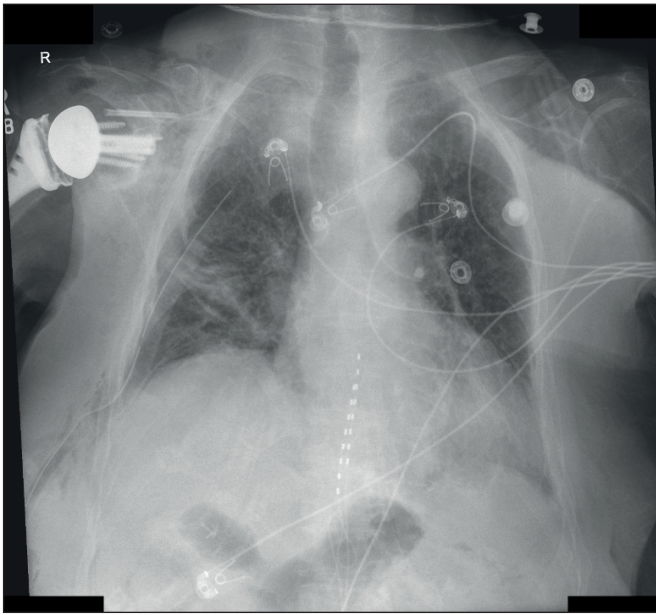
Chest X-ray after right chest tube placement with improvement of the right pneumothorax.
